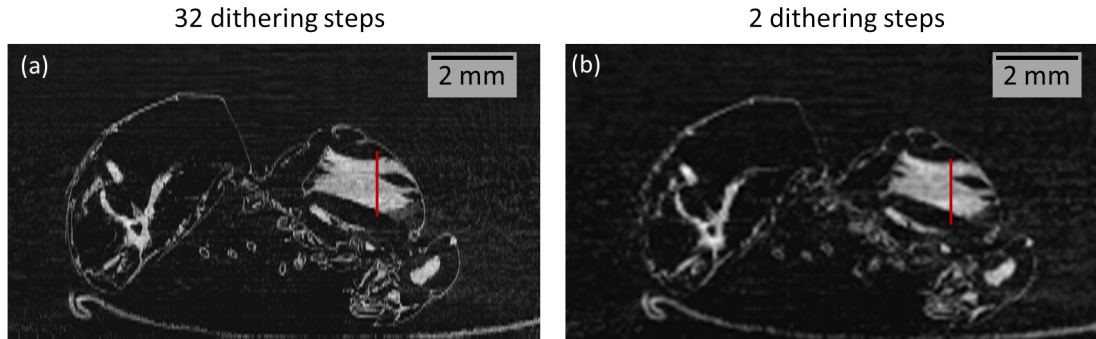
Coronal slices showing the RID of a domestic wasp, reconstructed from EI-CT datasets acquired with 32 (a) and 2 (b) dithering steps.
